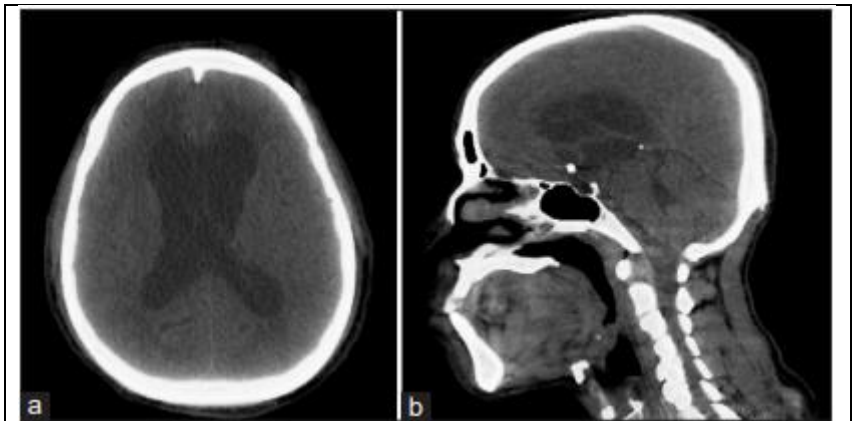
A diagnostic CT examination showing the vestibular schwannoma on the (a) axial and (b) sagittal CT.
